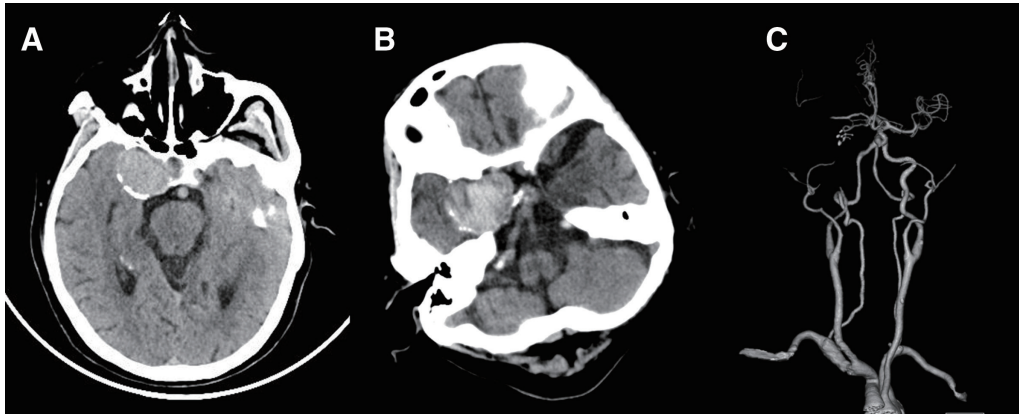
(A) A head CT scan 2 weeks prior to admission showed a giant unruptured intracranial aneurysm. (B) A head CT scan at admission showed an intraparenchymal mass (35 × 30 × 44 mm) with calcifications in the parasellar region. (C) CT angiography at admission reveals occlusion of the right MCA and invisibility of the cavernous segment of the right ICA. ICA: internal carotid artery; MCA: middle cerebral artery
